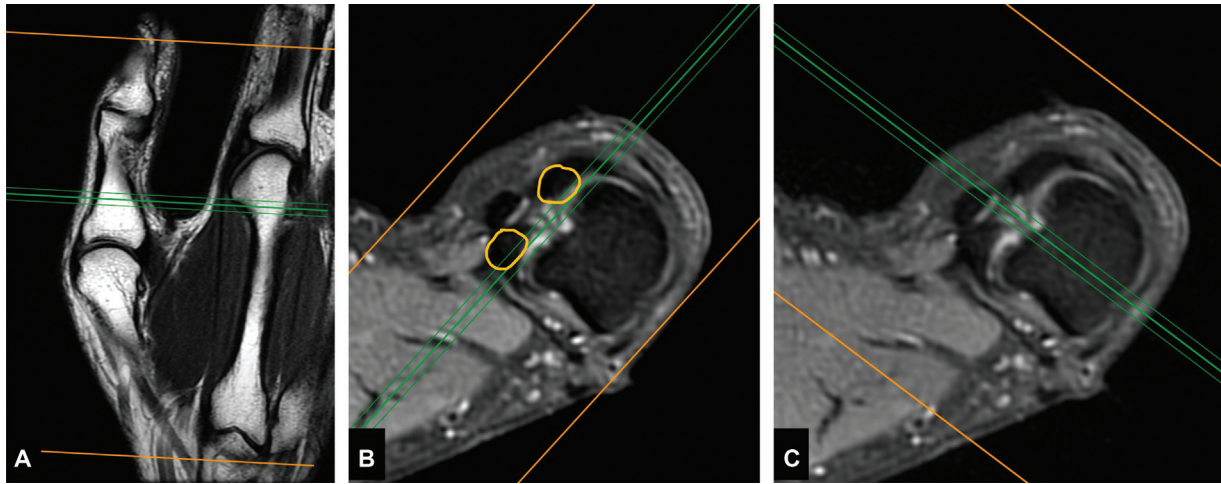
Planning of magnetic resonance imaging thumb. (A) First, localizer was used to plan axial images perpendicular to the long axis of the proximal phalanx. (B) Using axial images, coronal scan was planned parallel to the line joining the two sesamoids (outlined with yellow circle). (C) Using axial images, sagittal scan was planned perpendicular to the line joining the two sesamoids.
